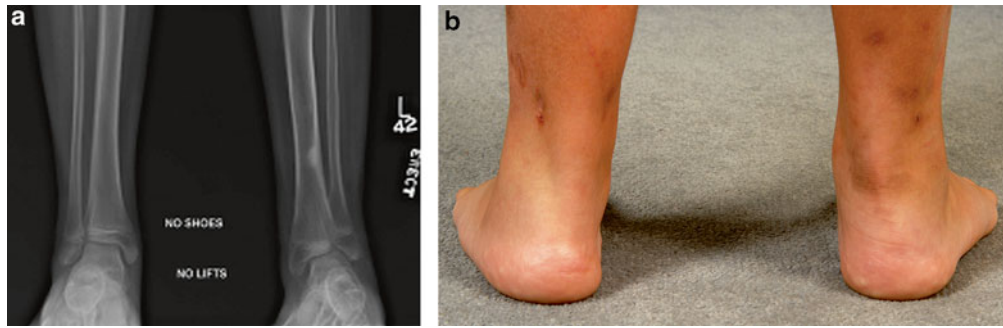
Radiographs (a) and clinical images (b) of a patient with distal tibial valgus and compensatory hindfoot varus. Note the radiographic valgus of the left ankle and the apparent normal clinical alignment of the left hindfoot
